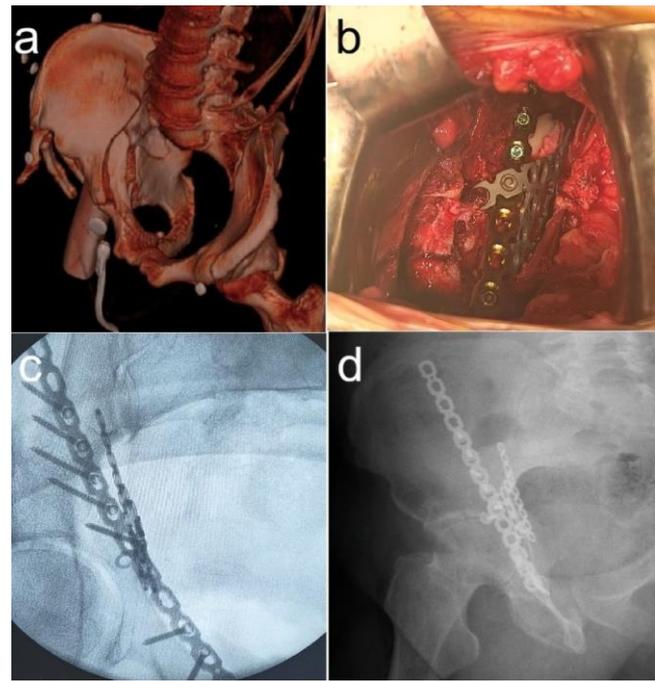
(a) Preoperative 3D computed tomography (CT) imaging of a 62-year-old male patient with a right acetabular and quadrilateral surface fracture. (b) Intraoperative view showing a contoured titanium locking calcaneus plate placed over a suprapectineal reconstruction plate for medial support. (c) Intraoperative fluoroscopy image. (d) Final follow-up radiograph at 1.5 years postoperatively.
